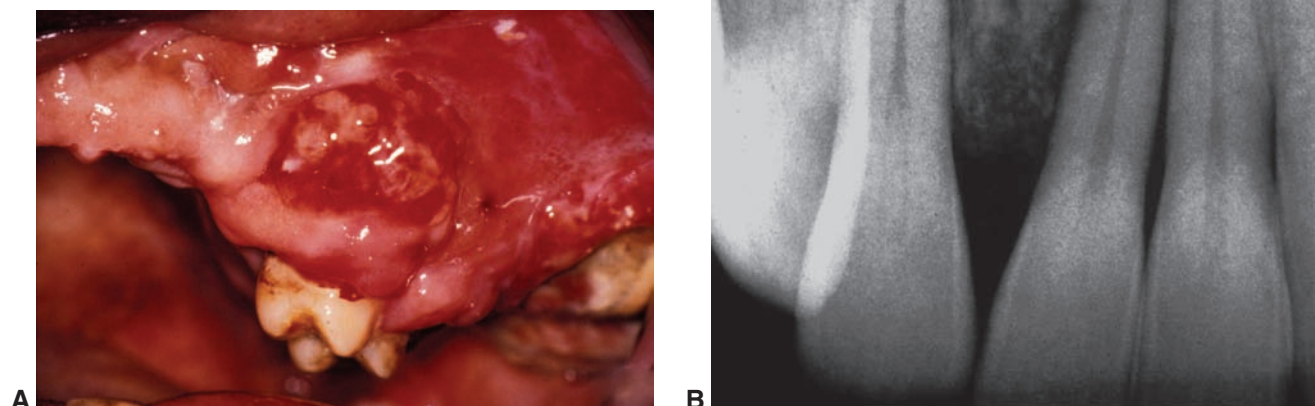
A. Clinical view of a chondrosarcoma. (Courtesy of Dr. Shabnum Meer.) B. Radiographic view of a chondrosarcoma. (Courtesy of Dr. Michael Kahn.)
